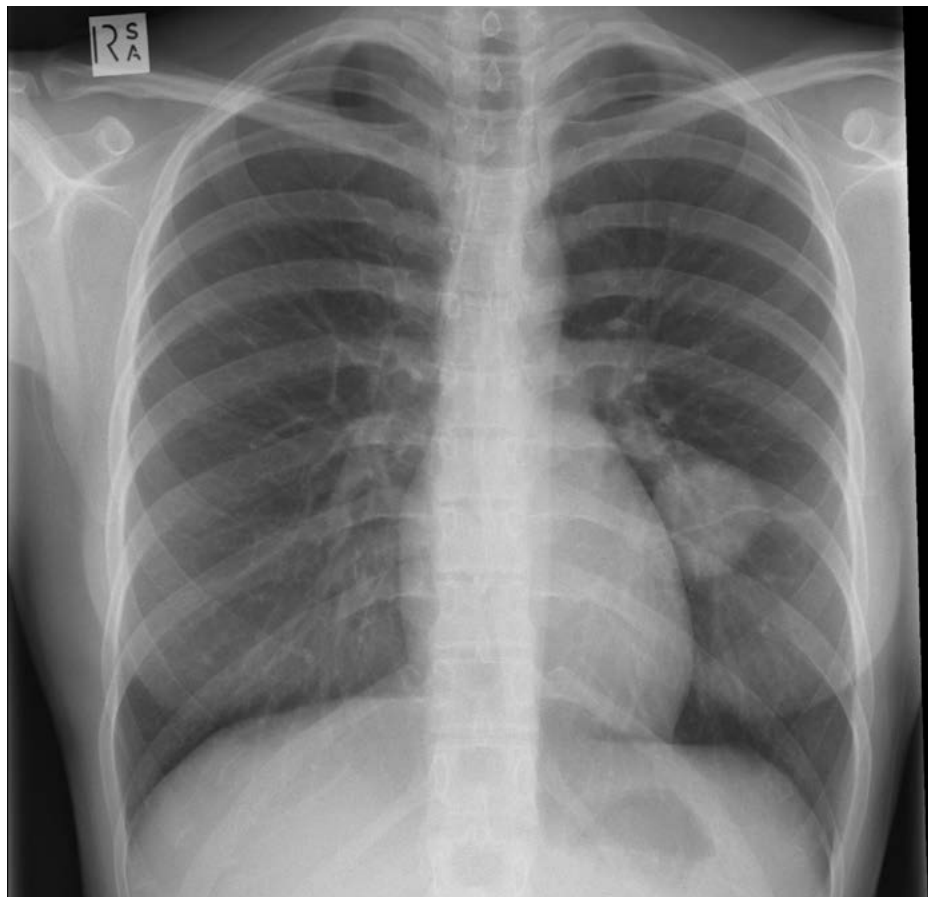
Chest radiograph revealing left lower lobe lung tumour.
